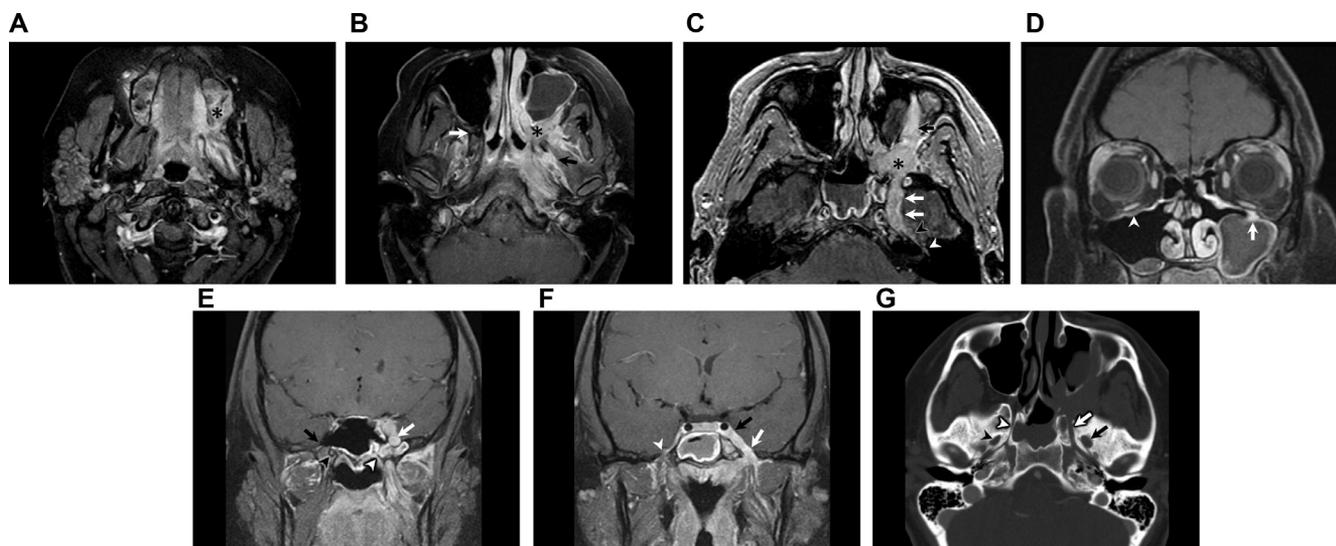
Surgically-proven adenoid cystic carcinoma of the left maxillary sinus with perineural tumor spread extending intracranially in a 22-year-old female with facial paresthesias. (A) Axial T1-weighted postcontrast fat-saturated image shows an infiltrative enhancing tumor within the eroded left superior alveolus and left hard palate (black asterisk). (B) Axial T1-weighted postcontrast fat-saturated image. Perineural spread of tumor extends into the left pterygopalatine fossa (black asterisk). There is also involvement of the left V3 (black arrow) which enhances abnormally just after exiting foramen ovale. Note the normal appearing right pterygopalatine fossa (white arrow). (C) Axial T1 weighted spoiled gradient fat-saturated image. There is extensive perineural spread of the tumor involving V2 branches from the left pterygopalatine fossa (black asterisk) including antegrade along the infraorbital nerve (black arrow) and retrograde to the left cavernous sinus and the Meckel's cave (white arrows). Perineural tumor spread from the 5th to 7th nerve branches is present with marked thickening of the left greater superficial petrosal nerve (black arrowhead) extending to the geniculate fossa (white arrowhead). D-F) Coronal T1-weighted postcontrast fat-saturated images. (D) There is perineural spread of tumor to the left CN V2 in the infraorbital groove (white arrow). Compare this to the normal-appearing nerve in the right infraorbital groove. (E) There is marked enlargement of left CN V2 in the foramen rotundum (white arrow) and the left vidian nerve within the vidian canal (white arrowhead). Compare these to the normal-appearing right foramen rotundum (black arrow) and right vidian canal (black arrowhead). (F). Perineural spread of tumor extends along the thickened left V3 in foramen ovale (white arrow). Perineural tumor spread expands the left cavernous sinus (black arrow). Compare this to the venous enhancement in the normal right foramen ovale (white arrowhead). (G) Axial contrast-enhanced CT in bone window shows abnormal widening of the left vidian canal (white arrow) and left foramen ovale (black arrow) secondary to perineural tumor spread. Compare these to the normal-appearing right vidian canal (white arrowhead) and right foramen ovale (black arrowhead).
